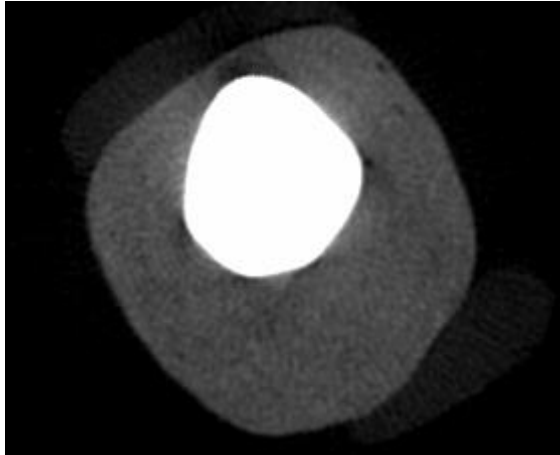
Cross-sectional image of micro-computed tomography of crown
